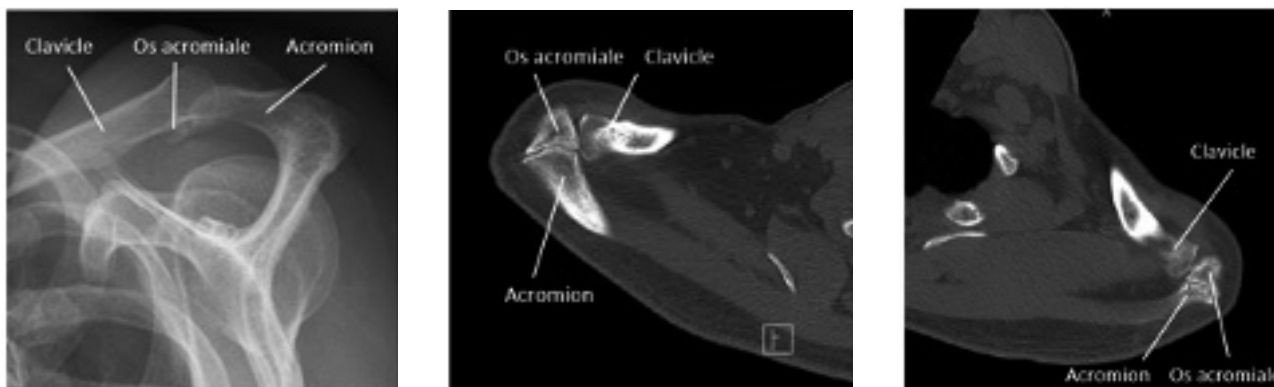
X-ray with axial incidence of the scapula in a 58-year-old woman: type B os acromiale (A). Arthro-scan of both shoulders in a 42-year-old man: bilateral type A os acromiale (B).
